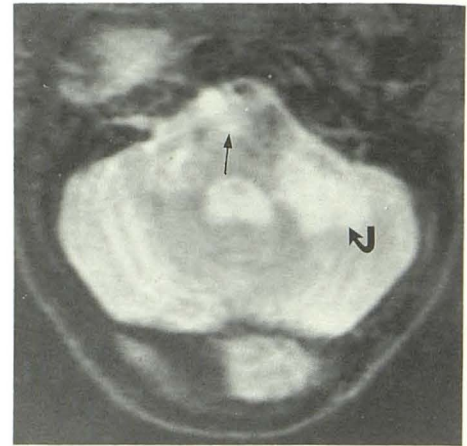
Case 25: 37-year-old man admitted with mental status changes. Axial T2-weighted MR image (2000/80) shows foci of hyperintensity involving the pons (straight arrow), left middle cerebellar peduncle, and adjacent cerebellum (curved arrow). These findings represent a case of AIDS encephalopathy with associated clinical toxoplasmosis. The patient's symptoms were relieved with antitoxoplasmoid medications.
